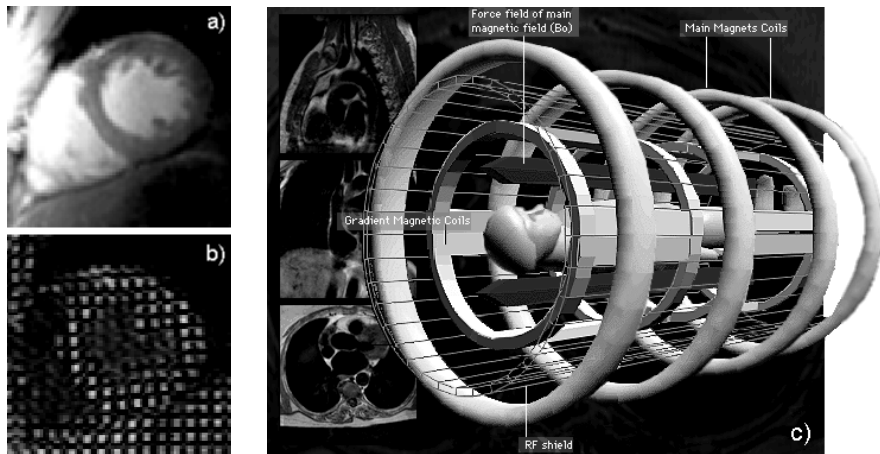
a) Myocardium seen in an ordinary MR image. Uniformity of the tissue and the lack of landmarks is well appreciated. b) Tags printed over the myocardium provided by MR tagging. c) MR Scanner device.
